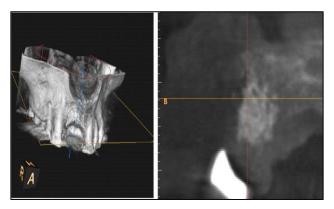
The area after 5 months, second CBCT
